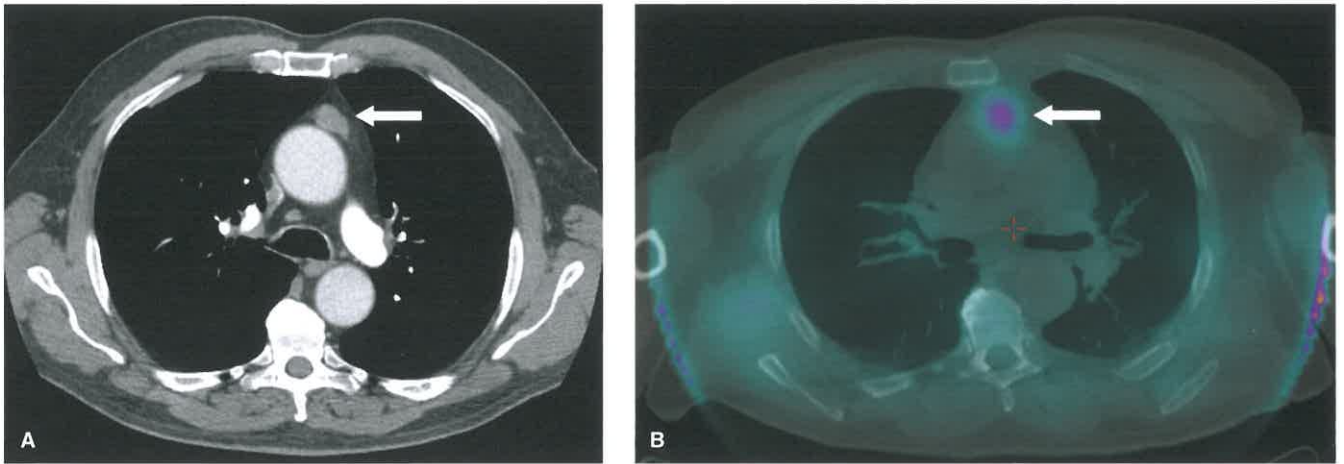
Parathyroid Adenoma. A: Axial contrast-enhanced CT through the upper chest in a 60-year-old male with hypercalcemia demonstrates a pre-aortic nodule (*arrow*). B: Fused SPECT-CT Tc-99m-sestamibi shows increased activity within the lesion (*arrow*). Surgical exploration confirmed an ectopic parathyroid adenoma.
